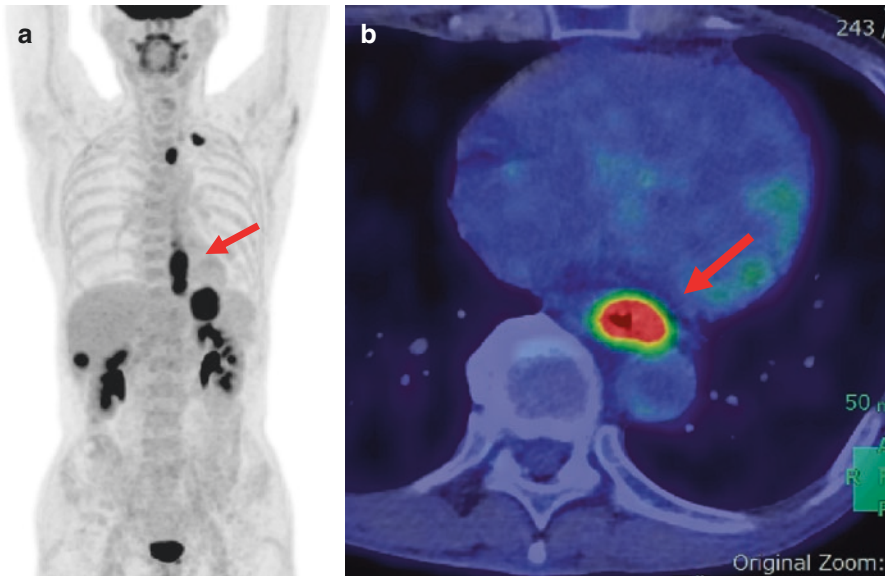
Detection of multiple metastases (a) MIP (maximum intensity projection) image of FDG-PET. Primary esophageal cancer was clearly revealed (arrow). (b) Image of esophageal cancer on axial section of PET/CT. (c) Detection of supraclavicular lymph node (arrow) is difficult by contrast-enhanced CT(CECT). (d) PET/CT apparently demonstrated the metastatic lymph node (arrow). (e) Liver metastases (arrow) is sometimes misdiagnosed for cyst only by CECT. (f) PET/CT showed a strong accumulation in liver metastases (arrow)
